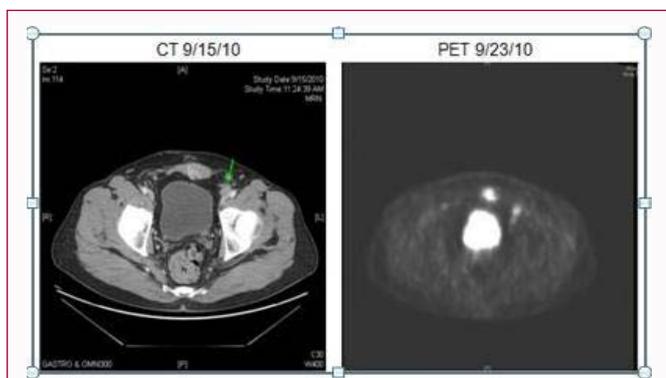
Case A. CT and PET scan performed 22 months after completing first-line therapy with HAI and systemic chemotherapy revealed a 2cm, hyper-metabolic, left external iliac lymph node (SUV 8.8) and a 2.3 x 2.5cm, hyper-metabolic mass in the left lower rectus muscle (SUV 7.5).
